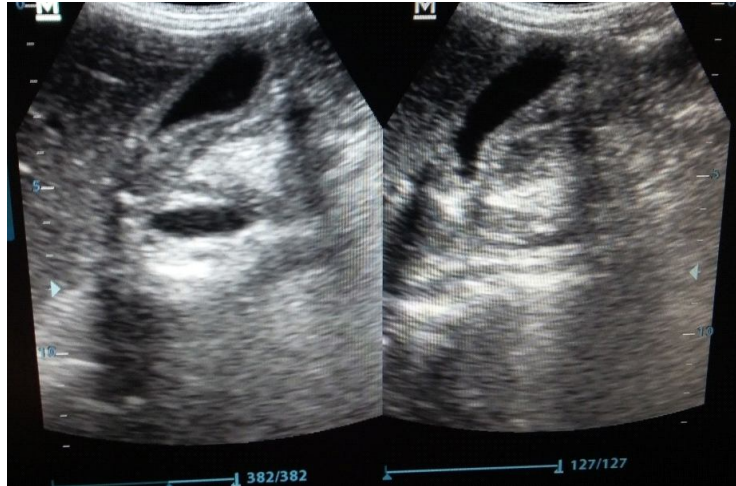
Ultrasound image of 36 years male showing acalculous cholecystitis
